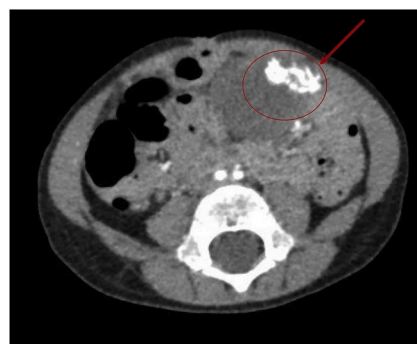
CT scan, Axial cut, showing the decreased size of the tumor after three cycles of treatment.
